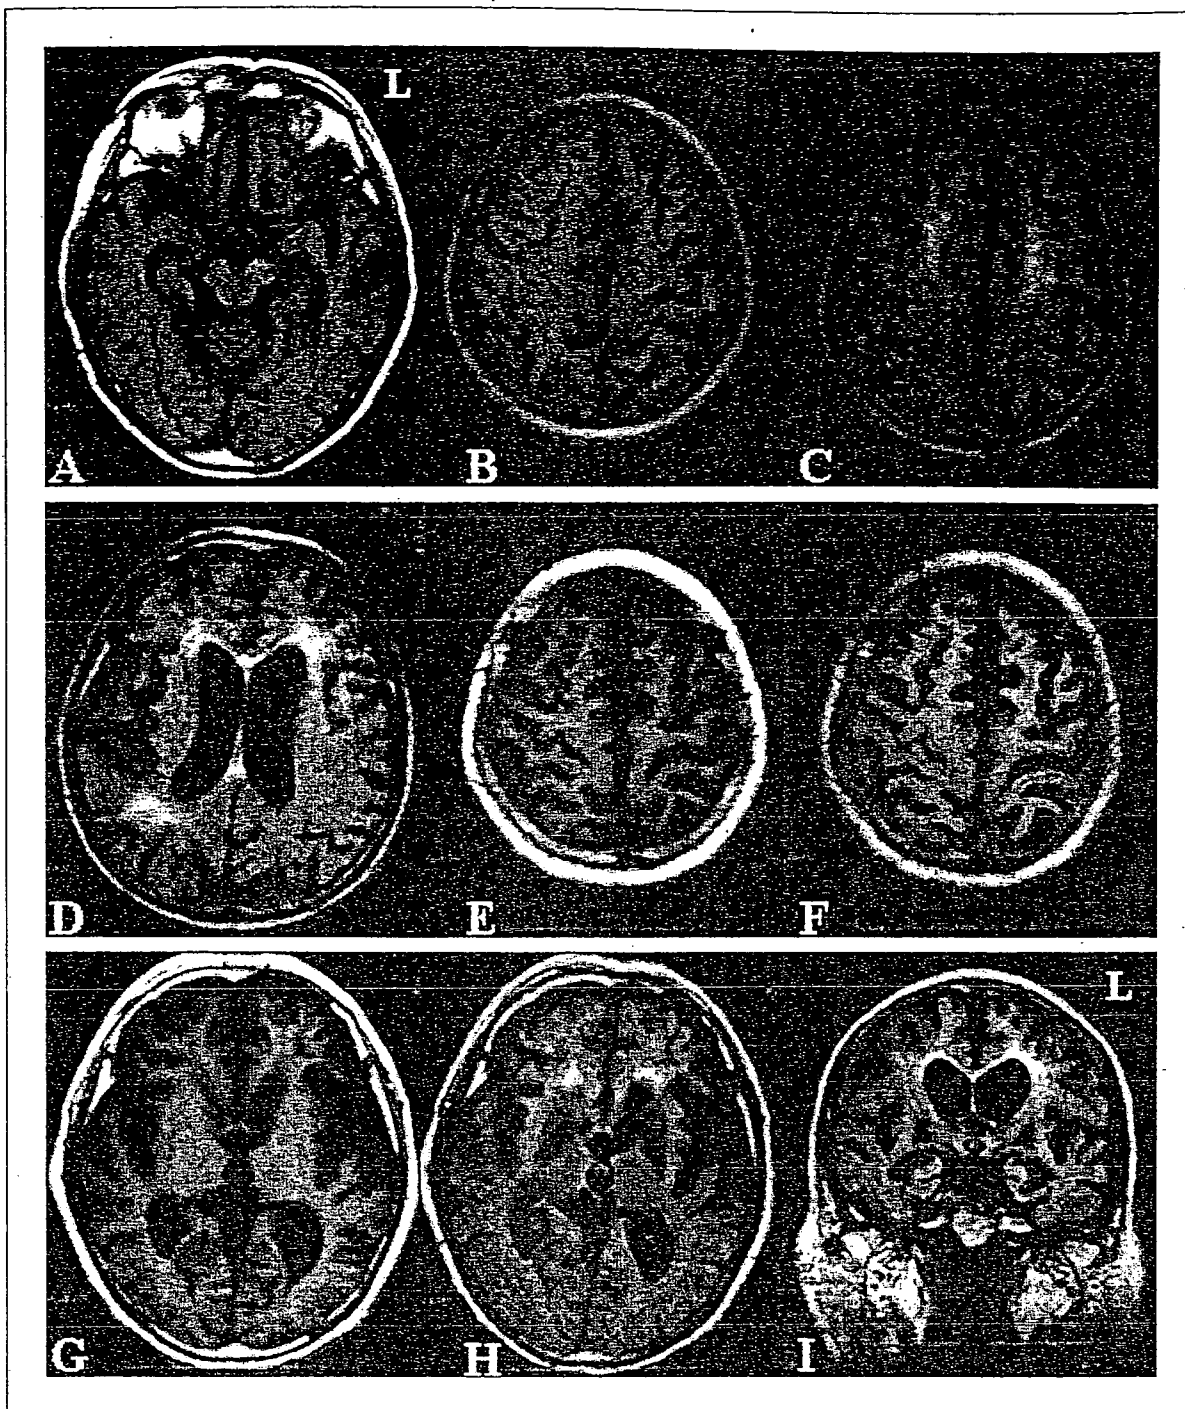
Magnetic resonance images taken at age 63 (A–D) and age 66 (E–I) show supratentorial ventricular dilation and prominent cortical sulci due to moderate to severe cortical atrophy. There is mild to moderate nonspecific cerebral cortical atrophy without significant laterality. The hippocampal formation as well as basal ganglia appears to be normal in size (A–C). Periventricular hyperintensity of moderate degree suggestive of diffuse ischemia was present (D). There is progressive mild atrophy in the paracentral cortex with predominance on the left side (B, C, E, F). The bilateral putamina are atrophic without signal decrease indicative of increased iron deposition (G, H). The hippocampal formation associated with dilatation of the inferior horn of the lateral ventricles is also noted (I). There are hypointense lesions at the level of the globus pallidus and hyperintense lesions in the cerebral white matter (I). (A, B, E, G: T1-weighted image (TR 440, TE 16); C, D, F, H, I: FLAIR (TR 8802, TE 112).)
